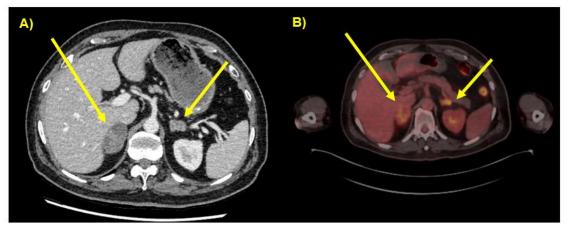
A) CT abdomen axial slice with arrows demonstrating bilateral adrenal masses. These demonstrated elevated Hounsfield Units and delayed contrast washout. B) FDG-PET axial slice with arrows demonstrating avid uptake in the adrenals bilaterally (SUVmax 5.3 right, 6.7 left).
